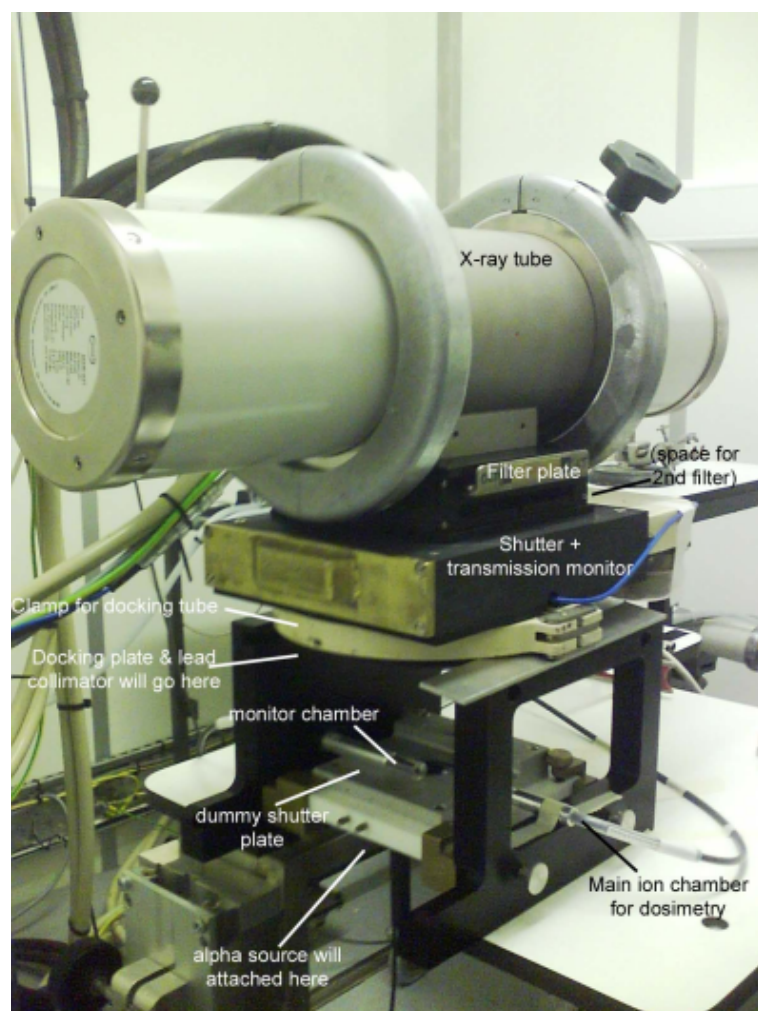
Photograph of the mixed alpha particle and X-ray setup*
